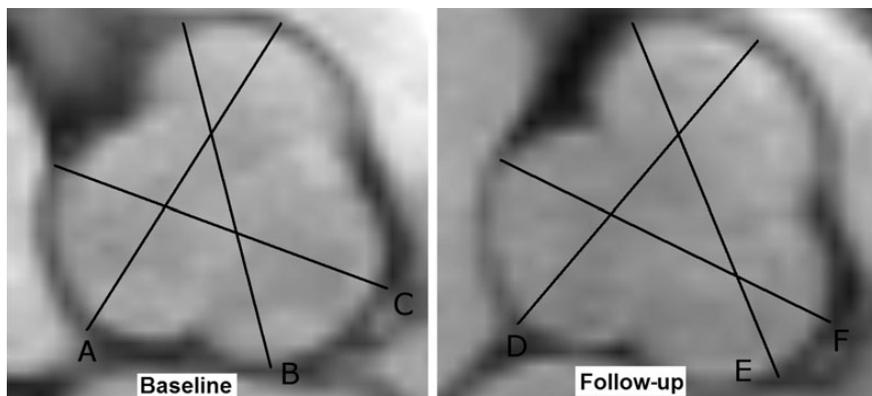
Magnetic resonance images showing the aortic root in short axis of a COMPARE patient with Marfan syndrome at baseline and after 3 years of follow-up. Greatest aortic root diameter of three measured distances was used; (A and D) non coronary cusp to right coronary cusp increased from 41 to 43 mm; (B and E) right coronary cusp to left coronary cusp increased from 42 to 44 mm; (C and F) non-coronary cusp to left coronary cusp increased from 41 to 42 mm.
